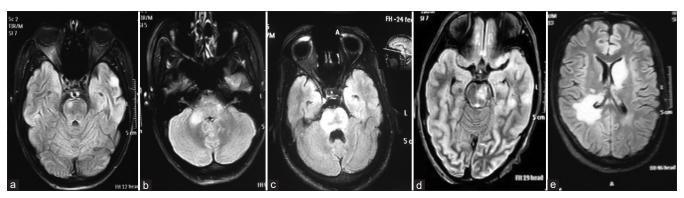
(a) MRI brain FLAIR axial sequence showing hyperintense signal in right side of pons. (b) MRI brain FLAIR axial sequence showing hyperintense signal in right middle cerebellar peduncle. (c) MRI brain FLAIR axial sequence showing confluent hyperintense signals in pons. (d) MRI brain FLAIR axial sequence showing hyperintense signal in left side of midbrain. (e) MRI brain FLAIR axial sequence showing fluffy hyperintense signal in left caudate nucleus and right thalamus with adjoining periventricle and subcortex in MOG antibody positive patient
